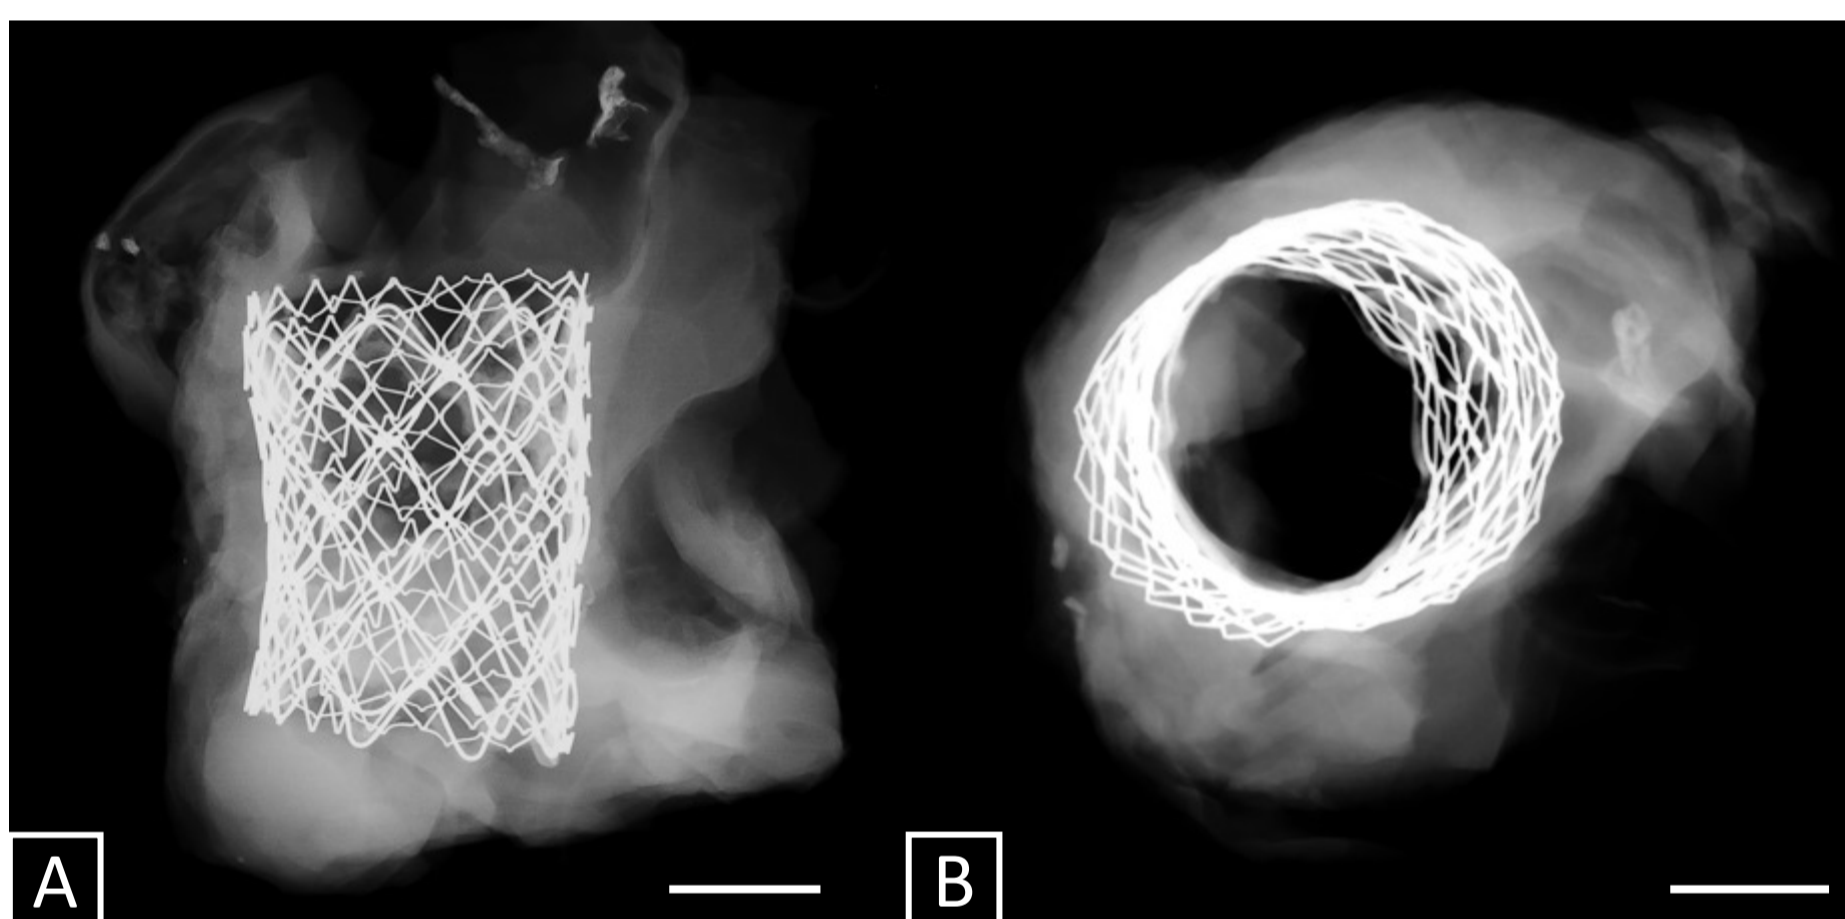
(A) Lateral and (B) oblique views of Faxitron® high resolution x-ray imaging of the stents and bioprosthetic cusps. No stent fracture was visible. Scale bar = 1 cm.
